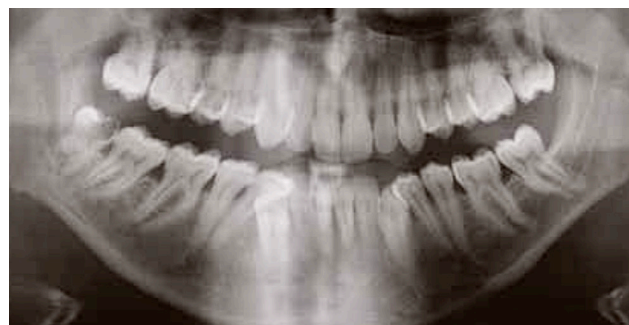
Orthopantomography showing severe decay on tooth 48 and overlap of the neurovascular bundle with root block
